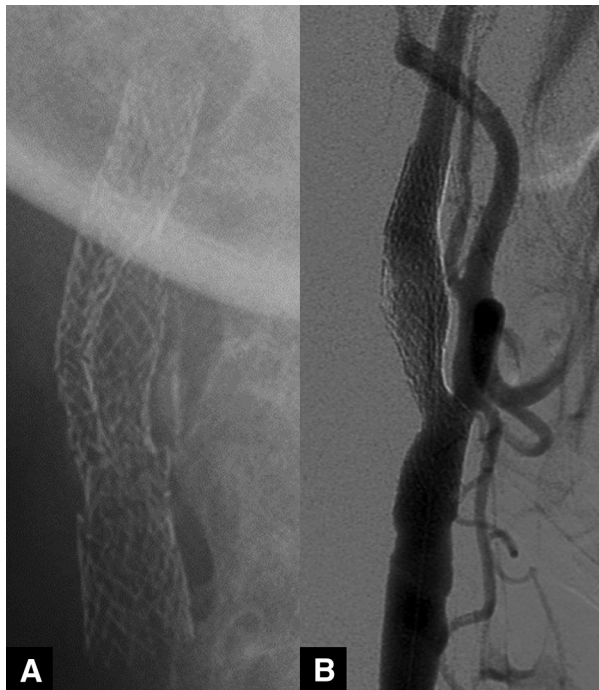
Stent fracture is seen on postoperative X-ray (A). Improved blood flow on DSA (B).
